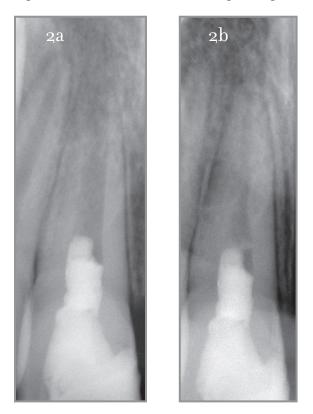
Postoperative radiograph after clot induction and direct restoration. Figure 2b: Radiograph at 12.5-month follow-up showing continued radicular wall thickening, apical closure, and narrowing of the canal space.
